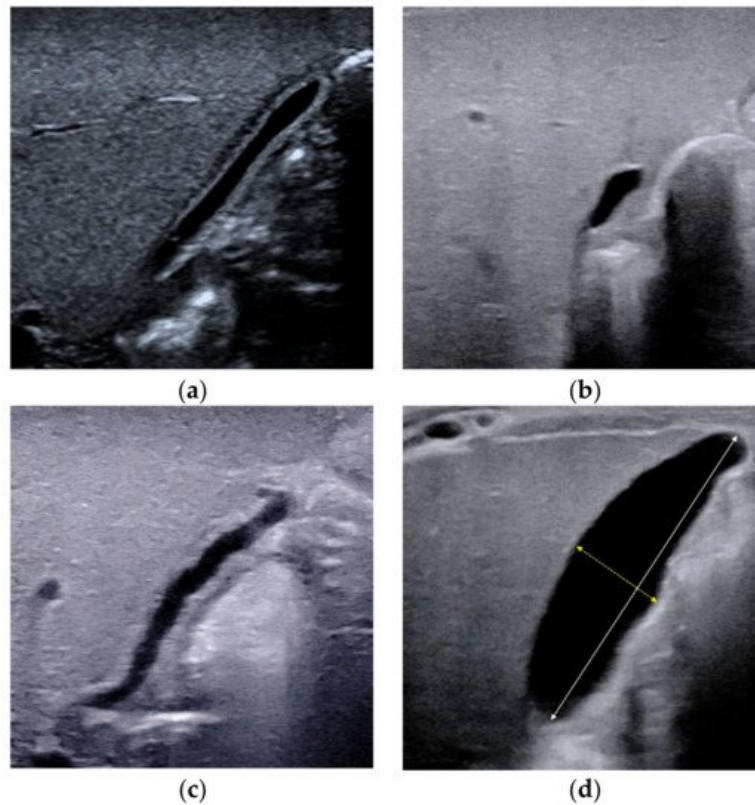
Different types of gallbladders detected by conventional ultrasound. (a) Type II gallbladder in non-BA. (b) Type III gallbladder in BA. (c) Type IV gallbladder with length-to-width ratios of >5.2 in BA. (d) Type IV gallbladder with length-to-width ratios of ≤ 5.2 in non-BA. The maximum lumen length and width should be measured from inner wall to inner wall.
